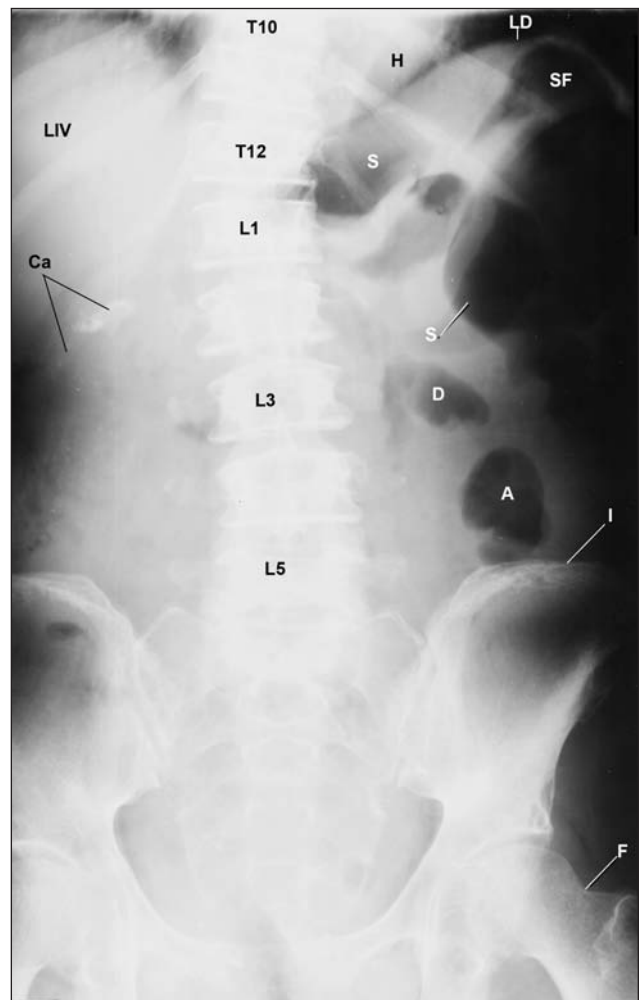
In this anteroposterior radiograph of the abdomen, ascites obscures the psoas margins (fatty envelope) and the duodenum (D), which is displaced to the left of midline. The dilated descending colon (SF) displaces the stomach (S) into the left upper hypochondrium. A calcified density (Ca) is present over the region of the left kidney and to the right of midabdomen, below the liver (LIV). Observe the mild left concave scoliosis of the thoracolumbar spine (T10-L5). A = antrum of stomach; F = femur; H = heart; I = iliac bone; LD = left hemidiaphragm, L1-5 = lumbar vertebrae; T10-T12 = thoracic vertebrae.
